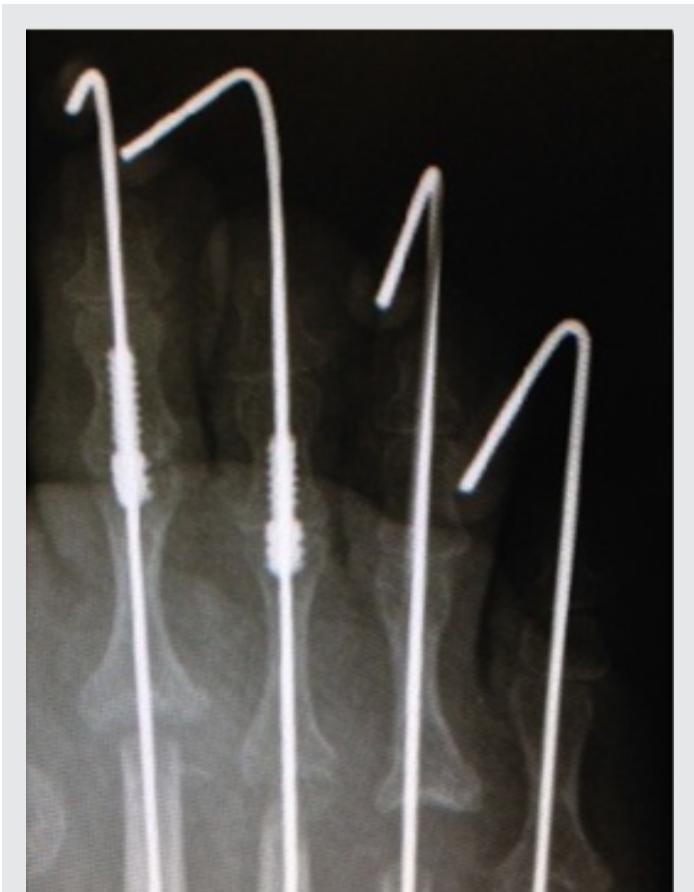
Anterior posterior radiograph of digital fusion and cannulated guide pin. The pin crosses and stabilizes the MTPJ.
